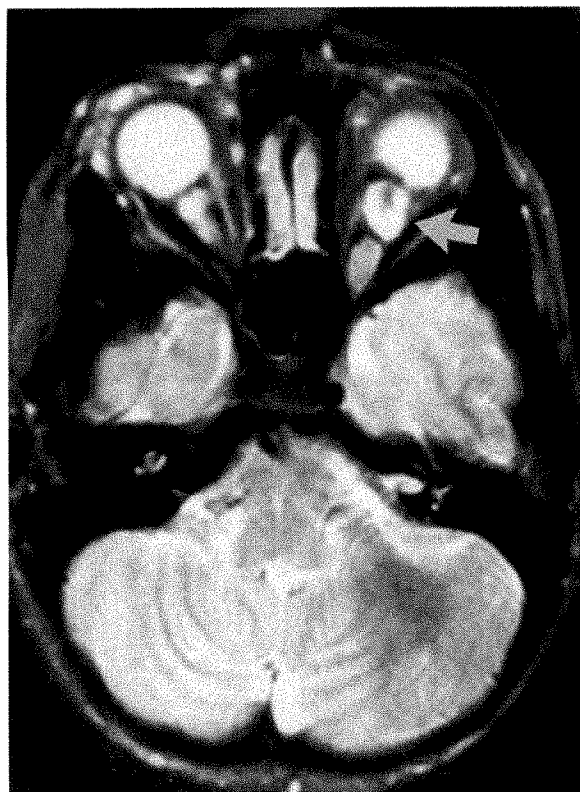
(Imes and Hoyt). Case 2. T₂-weighted axial magnetic resonance image. Anteriorly in the left optic nerve, an area of high signal intensity surrounds a core of lower signal intensity (arrow).
